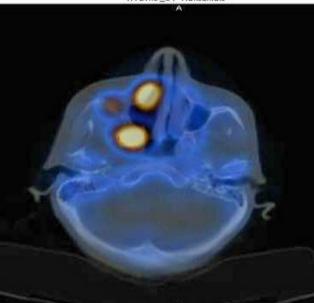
Figure 2. Axial SPECT-CT scan showing increased uptake of the maxillary sinus extending to involve the right wing of sphenoid bone with cheekbone lysis
